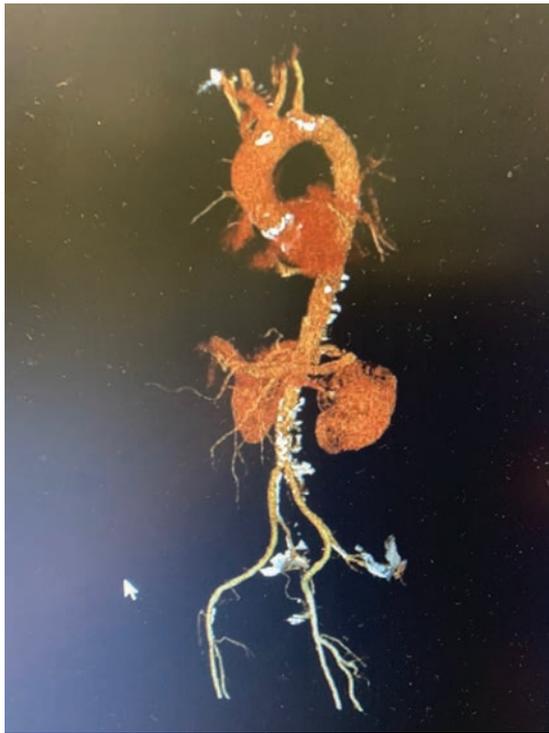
CTA demonstrating the entire aorta and iliofemoral arteries as part of the pre-TAVR workup.
